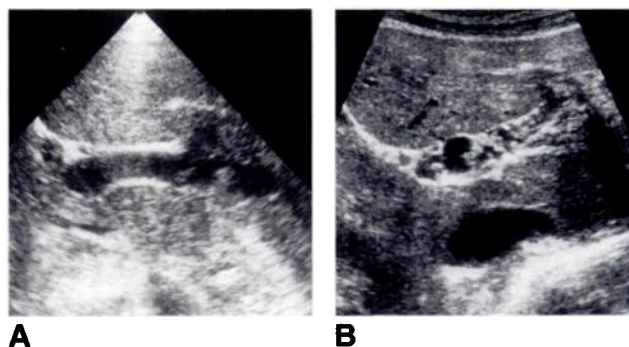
Formation of cavernoma and extension into left portal vein. A and B, Oblique sonograms of left side of liver show that left portal vein is distended with fresh thrombi (A) and that, a few days later, "spongy appearance" of cavernoma has replaced left portal vein (B).
